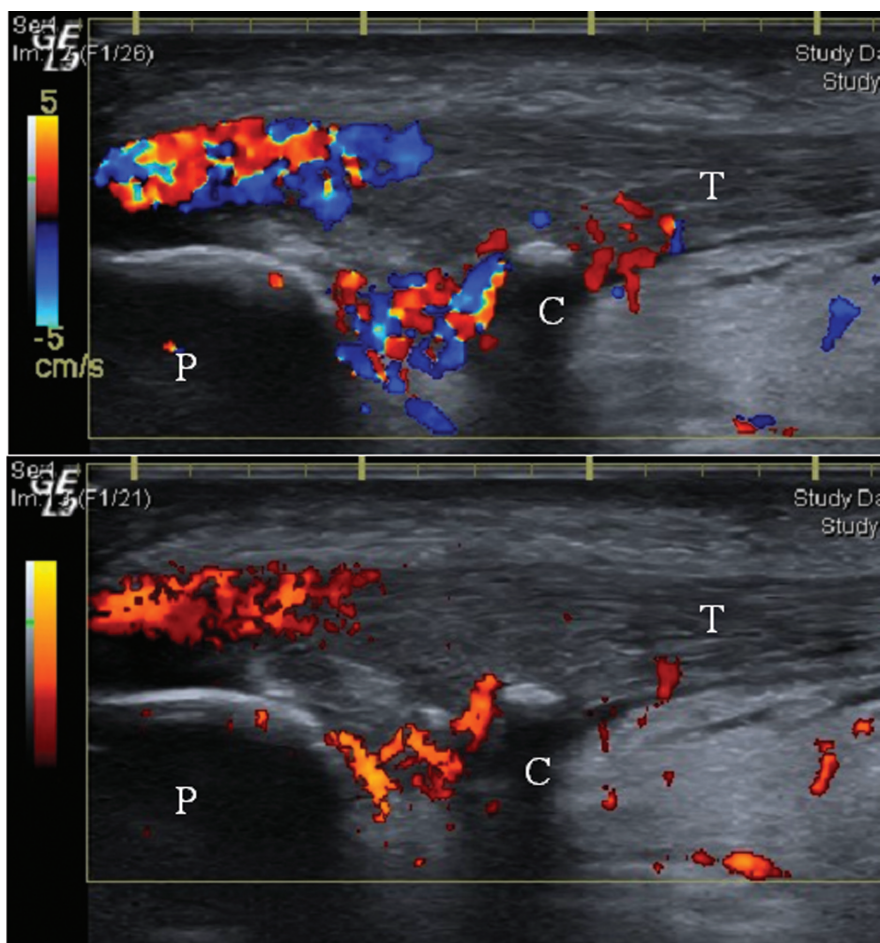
Colour versus power Doppler in Jumpers knee. A longitudinal scan showing Doppler activity inside the infrapatellar tendon. P: patella bone; T: tendon; C: intratendinous calcification. The top image shows colour Doppler and the bottom power Doppler. The power Doppler gain has been adjusted too high in an attempt to match the sensitivity of colour Doppler. Tiny noise pixels are seen in the bottom of the image. The colour Doppler shows more true flow (higher sensitivity) with less noise and is therefore preferable on this machine.
